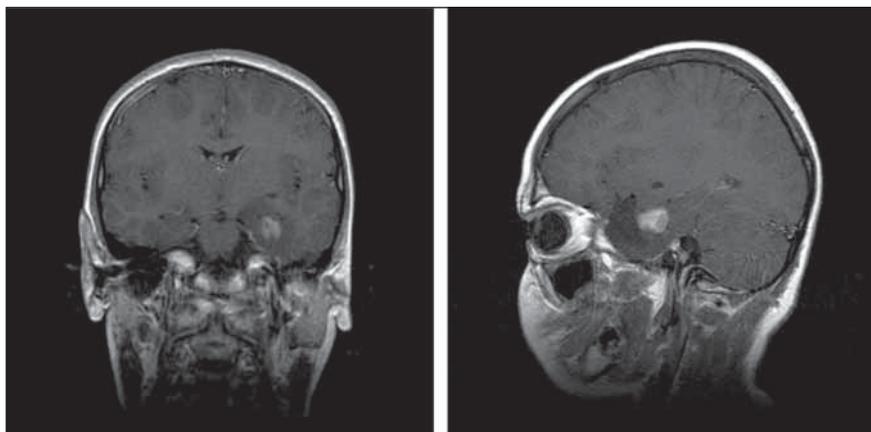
MRI with enhancement
